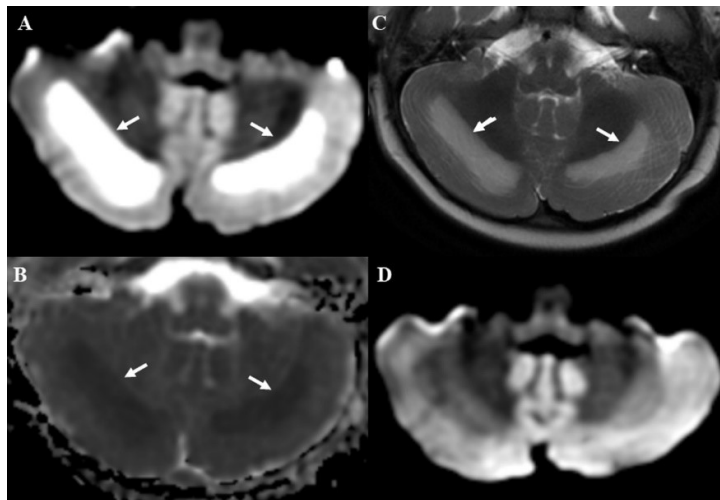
Image of a 1.5-year-old girl who ingested oral cough syrup containing dextromethorphan hydrobromide for intermittent fever and dry cough and now presented with decreased responsiveness, a seizure episode and bilateral constricted pupils. Axial MR brain images (A: Diffusion weighted sequence, B: ADC map, C: T2W sequence) show features of DANCE syndrome. Symmetrical and confluent areas of restricted diffusion (arrows in A) with low values on ADC map (arrows in B) and corresponding hyperintense signal on T2W sequence (arrows in C) are seen in bilateral cerebellar hemispheres, indicating cerebellar edema. No diffusion restricting foci were seen in supratentorial white matter in this case (not shown). D. Follow up MR image (diffusion weighted sequence) done 2 weeks later in the patient shows no residual diffusion restriction in cerebellum.
